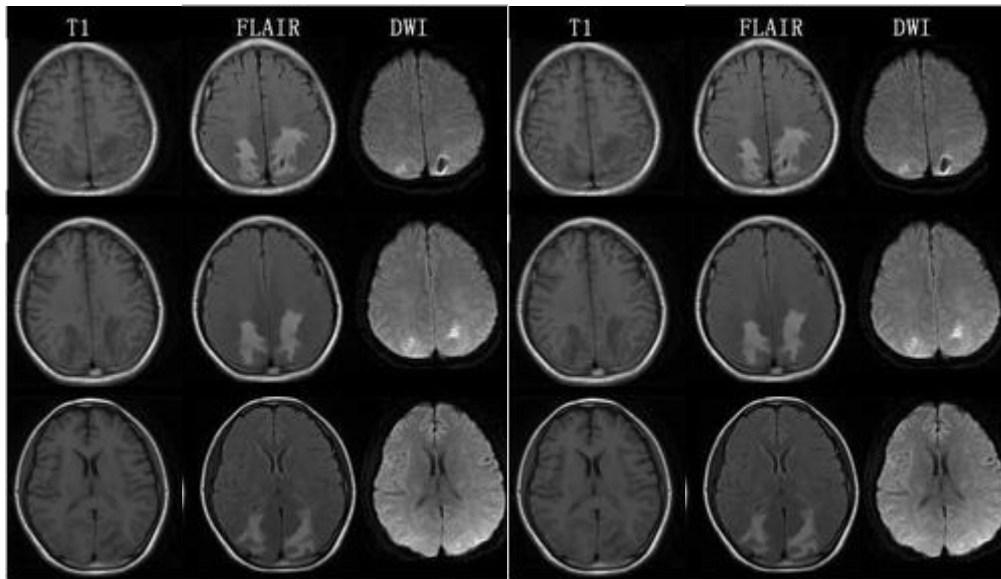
Sample Images from the database T1, Flair, DWI.
